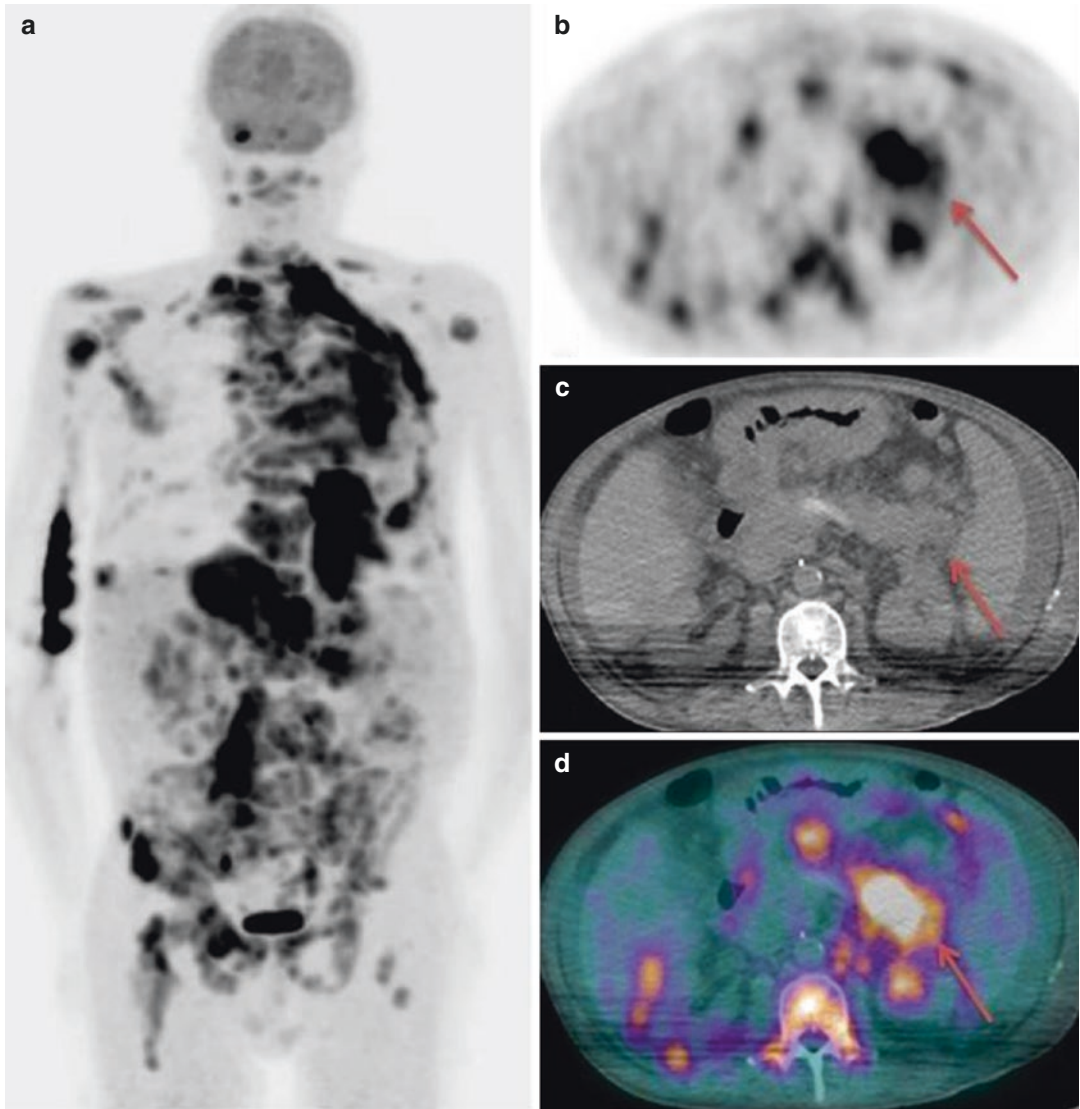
Patient with multiple metastases of unknown primary tumor. ^{18}F -FDG 3D PET Maximum intensity projection (a) shows multiple areas of pathologic tracer uptake in the brain, lungs, skeleton, thorax, and abdomen.
